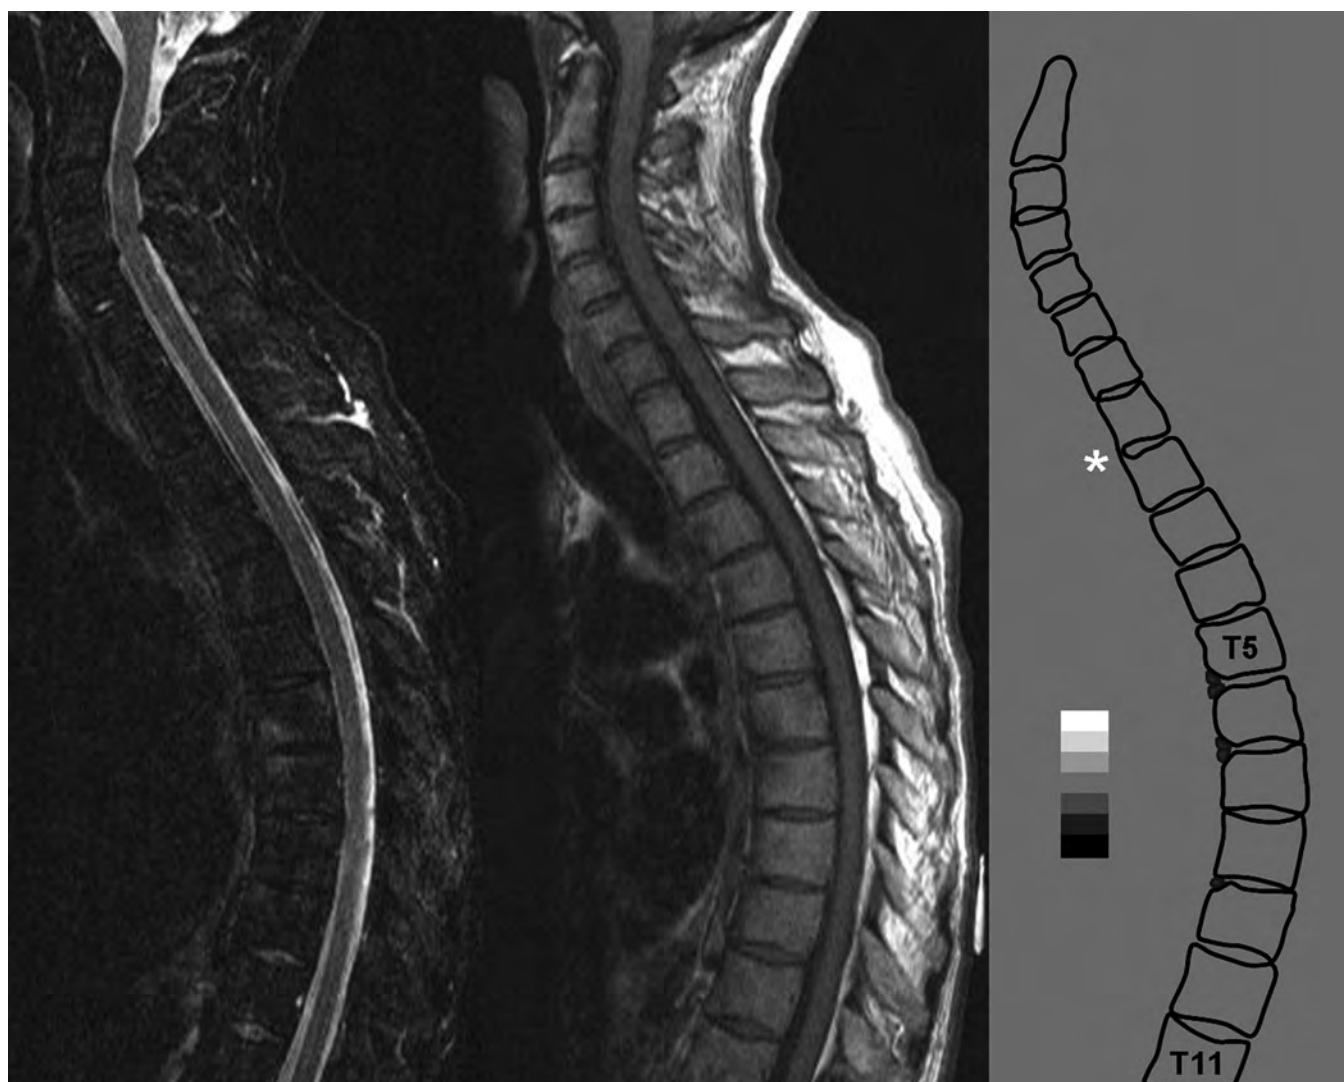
Corner bone erosion (COBE) and corner ankylosis (CANK). Scanning at large fields of view presents particular challenges. The smaller structures and suboptimal spatial resolution are sometimes compounded by limited image quality. In this MRI of the cervical and thoracic spine, subtle anterior corner bone erosions (aCOBE) are present at the threshold for detection at
